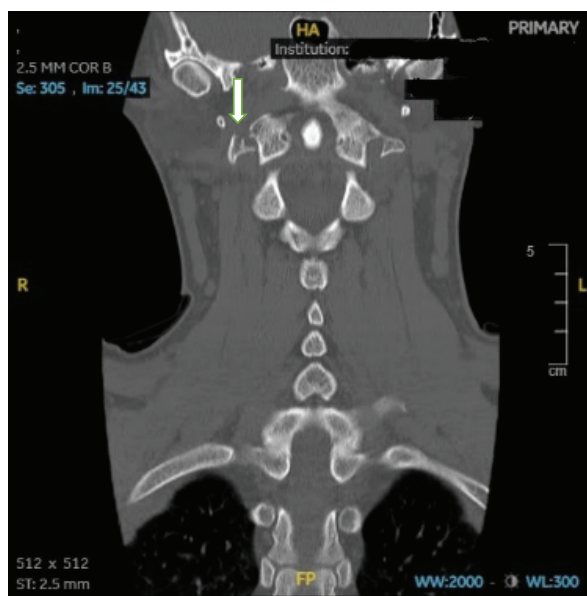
CT scan coronal section of cervical spine showing fracture of right transverse foramen of Atlas.
